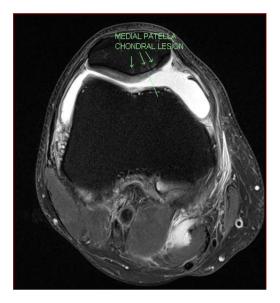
pre-treatment Fat-Suppressed T2 MRI demonstrating evidence of patellofemoral subchondral bone marrow oedema and cysts
